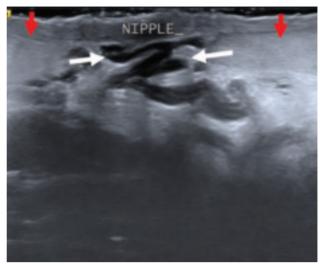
Ultrasonographic grayscale image of the left breast shows mildly dilated ducts (white arrows) with surrounding hyperechogenicity of the fat (red arrows) indicating soft tissue edema
